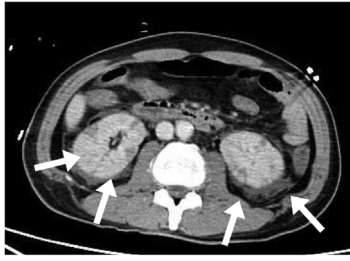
Computed tomography of abdomen: Kidney with intravenous contrast shows multiple low density lesions and surrounding dirty fat sign. (white arrow).
